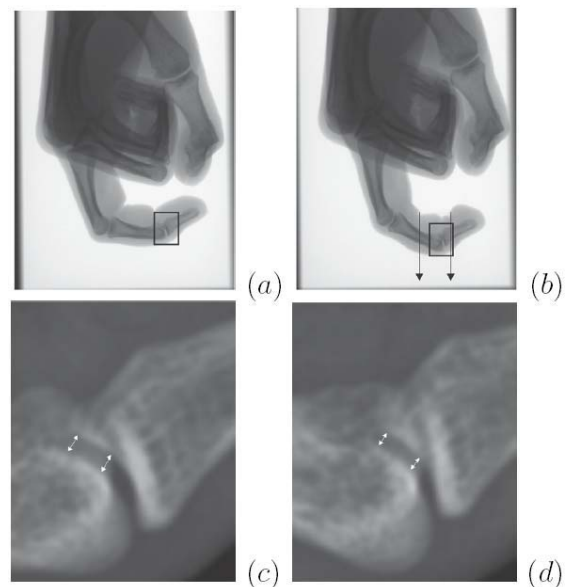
Reduction of joint space under tension is visible in x-ray images
